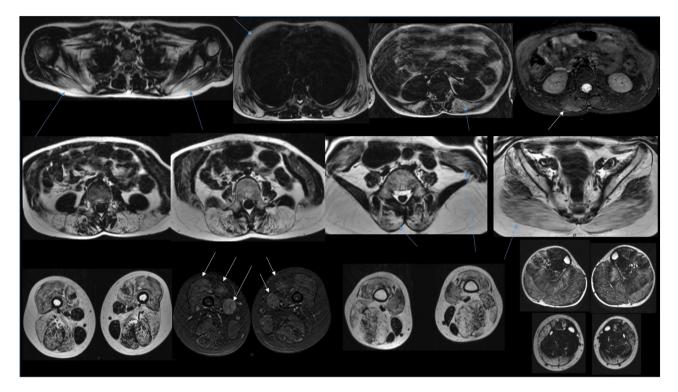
Whole-body muscle MRI in a patient with Duchenne dystrophy (Axial T2 Dixon "Fat" and "Water" images; Imaging Department, Raymond-Poincaré Hospital, AP–HP 2022). Note the symmetrical muscle damage, of proximal predominance. The muscle damage concerns mostly the pelvic girdle (particularly gluteus muscles), the quadriceps, the hamstrings (biceps femoris and semitendinosus) and the muscles of the posterior calf lodges (soleus, lateral and medial gastrocnemius but also the fibular) showing the classical "pseudohypertrophy" noted clinically. The scapular girdle and the axial paraspinal muscles are mildly affected. T2 hypersignal may be found in the active phase of the disease. The internal and external obturators, long adductors, gracilis and sartorius muscles are preserved.
